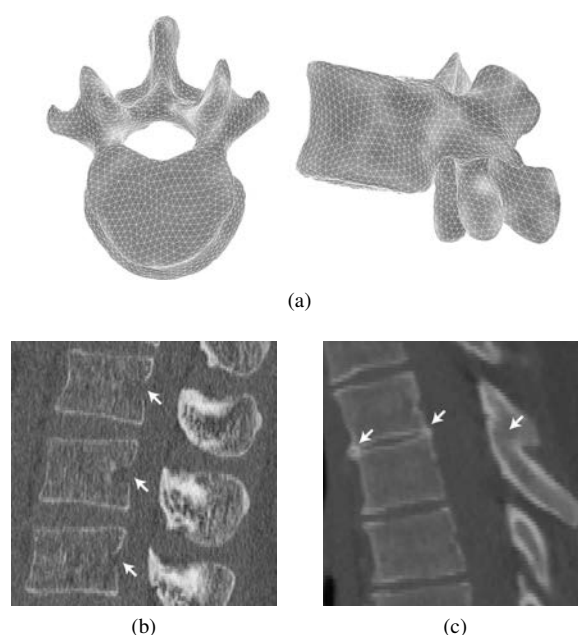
Detection and segmentation of vertebrae from CT images is a challenging task, for example, due to (a) high anatomical complexity (shown by a rendered 3D face-vertex surface mesh), (b) presence of unclear boundaries at the location of basivertebral veins (indicated by arrows in a sagittal cross-section), and (c) articulation of vertebrae with each other due to the degenerative disc and joint disease (indicated by arrows in a sagittal cross-section).
